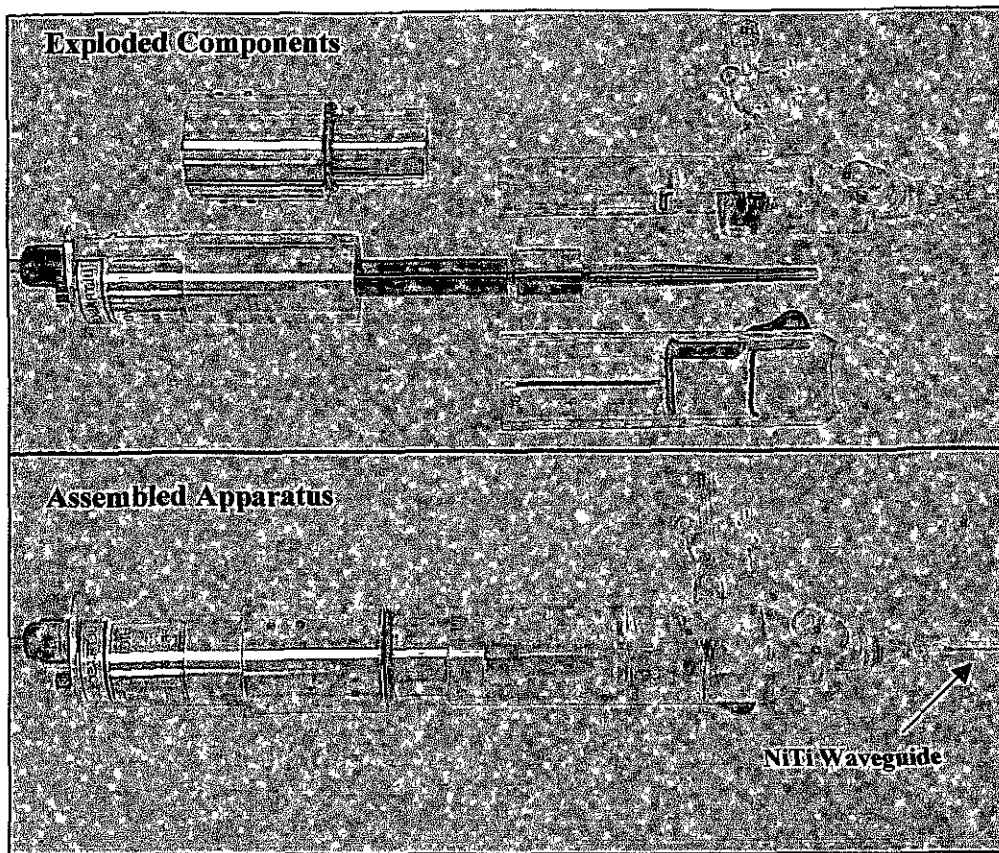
Image of ultrasonic wire waveguide apparatus in its housing with catheter emerging [47].
